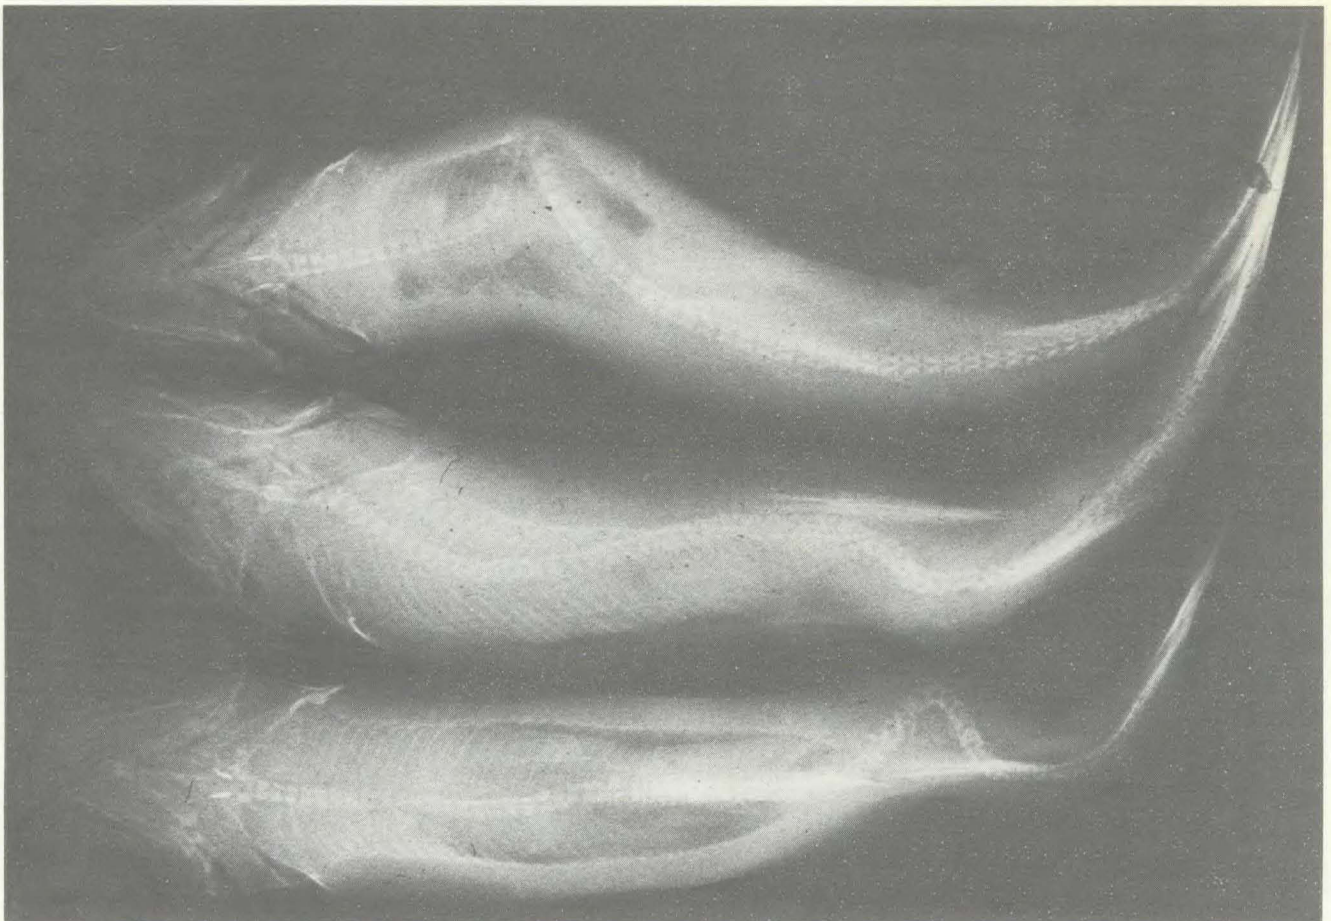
Ascorbic acid deficiency in rainbow trout results in bone deformities (scoliosis and lordosis) as shown in this X-ray of ascorbic acid deficient trout (Photo courtesy of B. Hicks).
